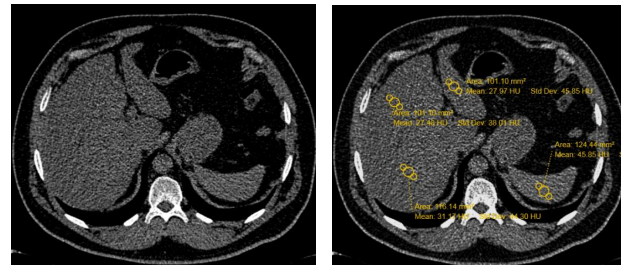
Non-contrast computed tomograms a 49-year-old man show fatty liver. The average HU of liver parenchyma is 28.87 HU, which is less more than 10 HU to spleen parenchyma HU
